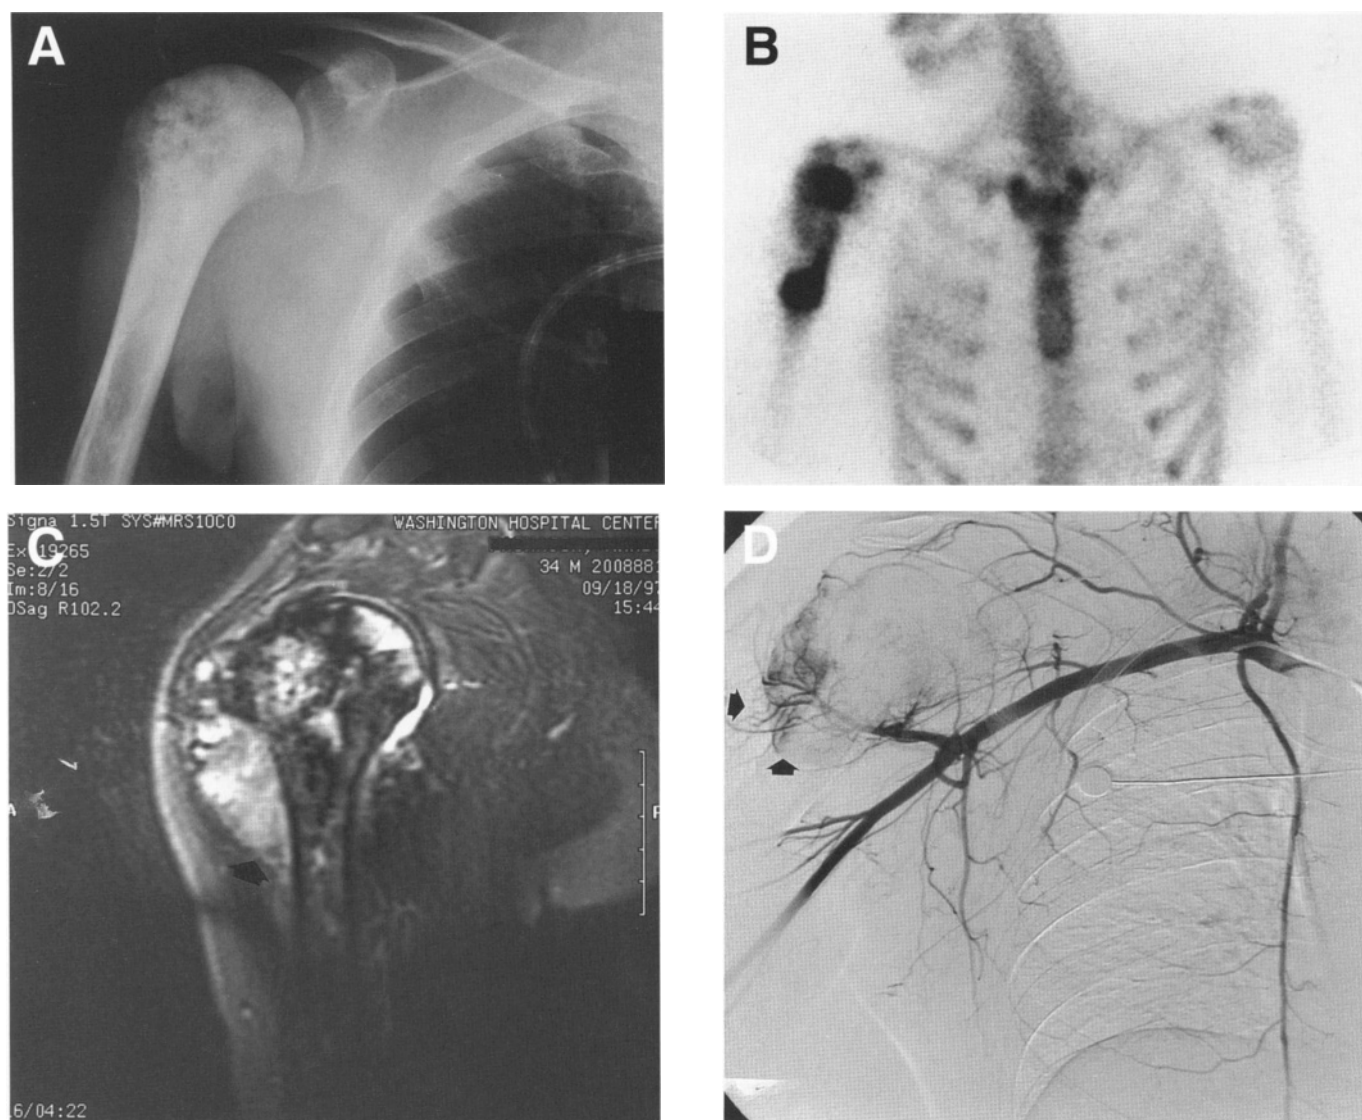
(see also following page) Typical case of osteosarcoma of the proximal humerus. (A) Plain radiograph showing a small sclerosing lesion of the proximal one-quarter of the humerus. This is typical of sclerosing osteosarcoma. (B) Bone scan corresponding with (A). (C) MRI of the same patient shows a large extraosseous component extending below the deltoid muscle (arrow). (D) Angiogram following induction chemotherapy showing minimal remaining tumor vascularity. Note that there is some tumor vascularity in the extraosseous component below the deltoid (arrows). There is no tumor vascularity of the main tumor intraosseously. (E) Postoperative radiograph showing the Modular Replacement System, following an extra-articular resection.
